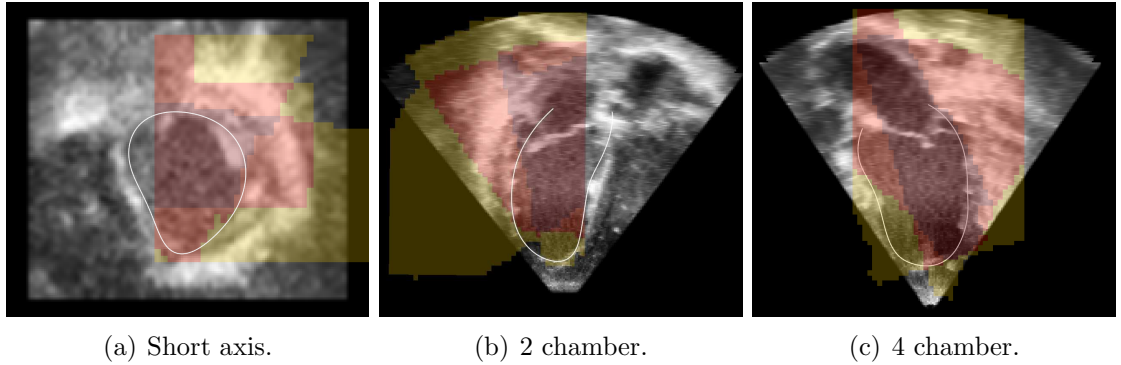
Coverage of left ventricle from multiple 3D colour Doppler views on a paediatric patient. Anatomical reference is provided by three orthogonal slices of a B-Mode image and a white line representing the ventricular wall. The number of views overlapping in each region is coded by colours: red = 3 or more views, orange = 2 views and yellow = 1 view.
